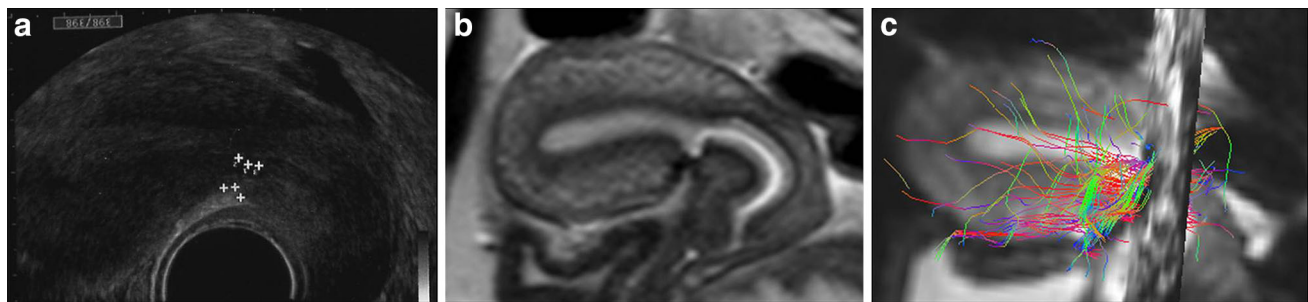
32-year-old woman with single caesarean delivery. a TVUS image of caesarean scar classified as linear. b Para-sagittal T2 Ssh-TSE MR image of the same scar classified as retracting c 3T-MR-DTI
